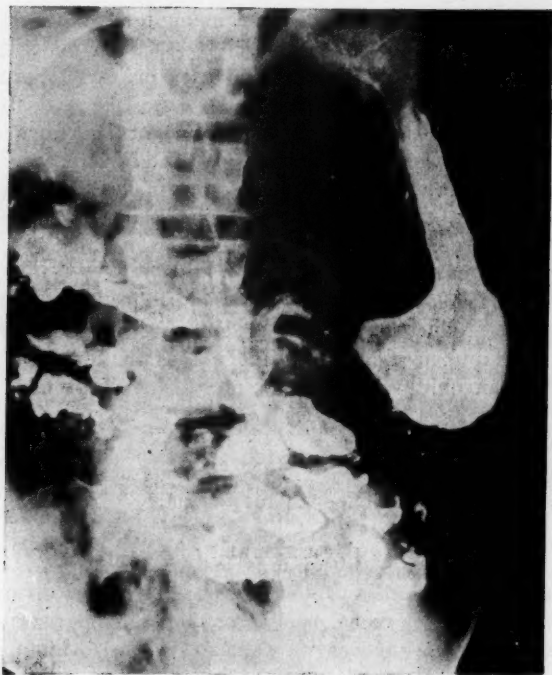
Upper gastrointestinal roentgenograms showing an unusual accumulation of barium in the upper small intestine.
